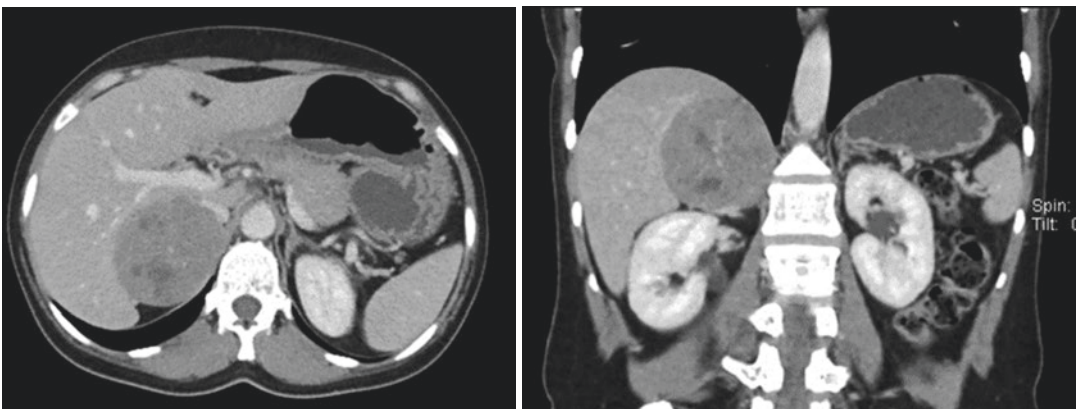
The hypodense solid mass in right adrenal gland in portal venous phase axial and coronal computed tomography images
